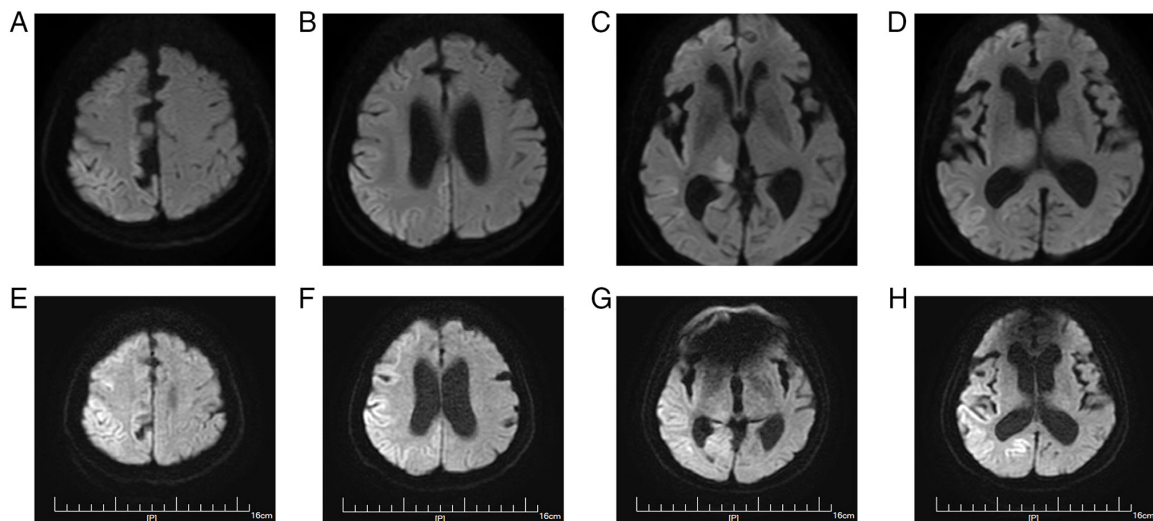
Brain magnetic resonance imaging performed in August 2025, 3 days prior to admission to Hebei General Hospital. (A-D) DWI performed at symptom onset demonstrates (C) hyperintensity in the right thalamus. (E-H) Follow-up DWI (3 days later, at 1 day post-admission) showed (G) reduced right thalamic hyperintensity and (H) new right occipital lobe signal abnormality.
